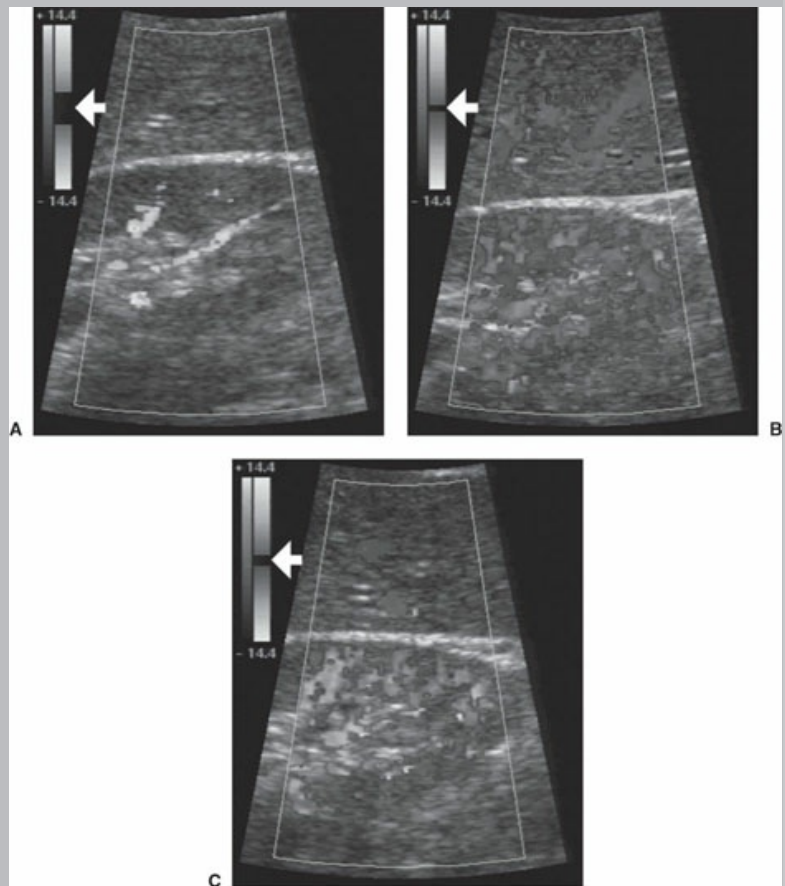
Doppler noise and the wall filter (arrow). A. High filter setting produces minimal flow detection. B. Low filter setting produces excessive noise. C. Medium filter setting eliminates noise and correctly depicts flow. Color image provided online.
